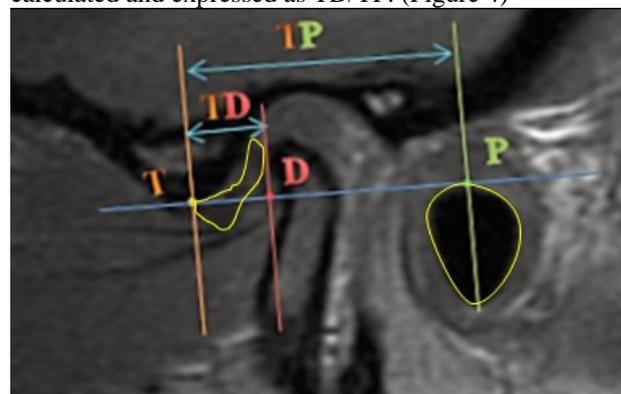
Showing MRI application of Kurita et al method for measuring the articular disc position.
